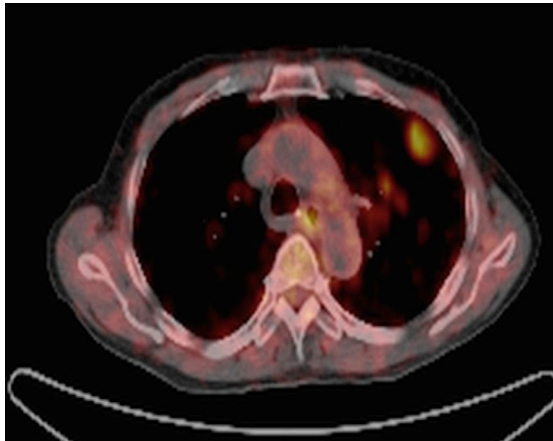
CT-PET scan of mid oesophageal malignancy with lung metastasis
